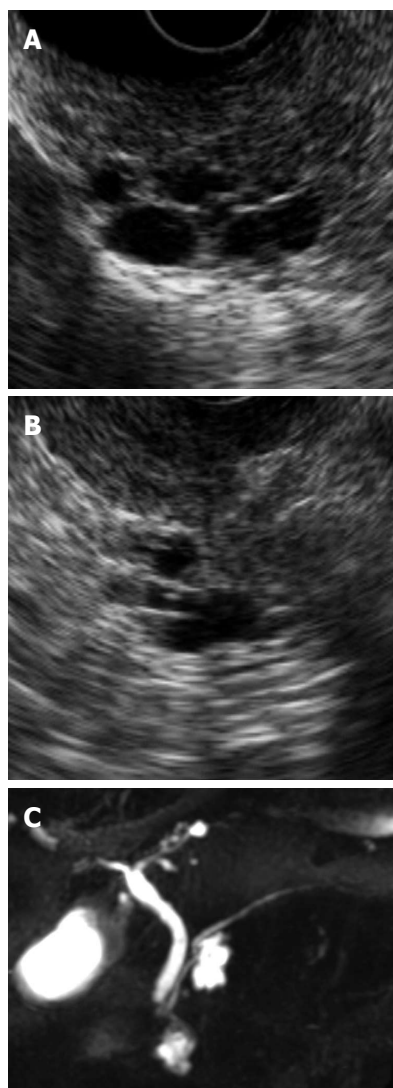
Imaging studies from the initial examination. A, B: Endoscopic ultrasonography showed 2 multilocular cysts in the pancreas head; C: Magnetic resonance cholangiopancreatography showed 2 cystic lesions without dilation of the main pancreatic duct in the pancreas head.
